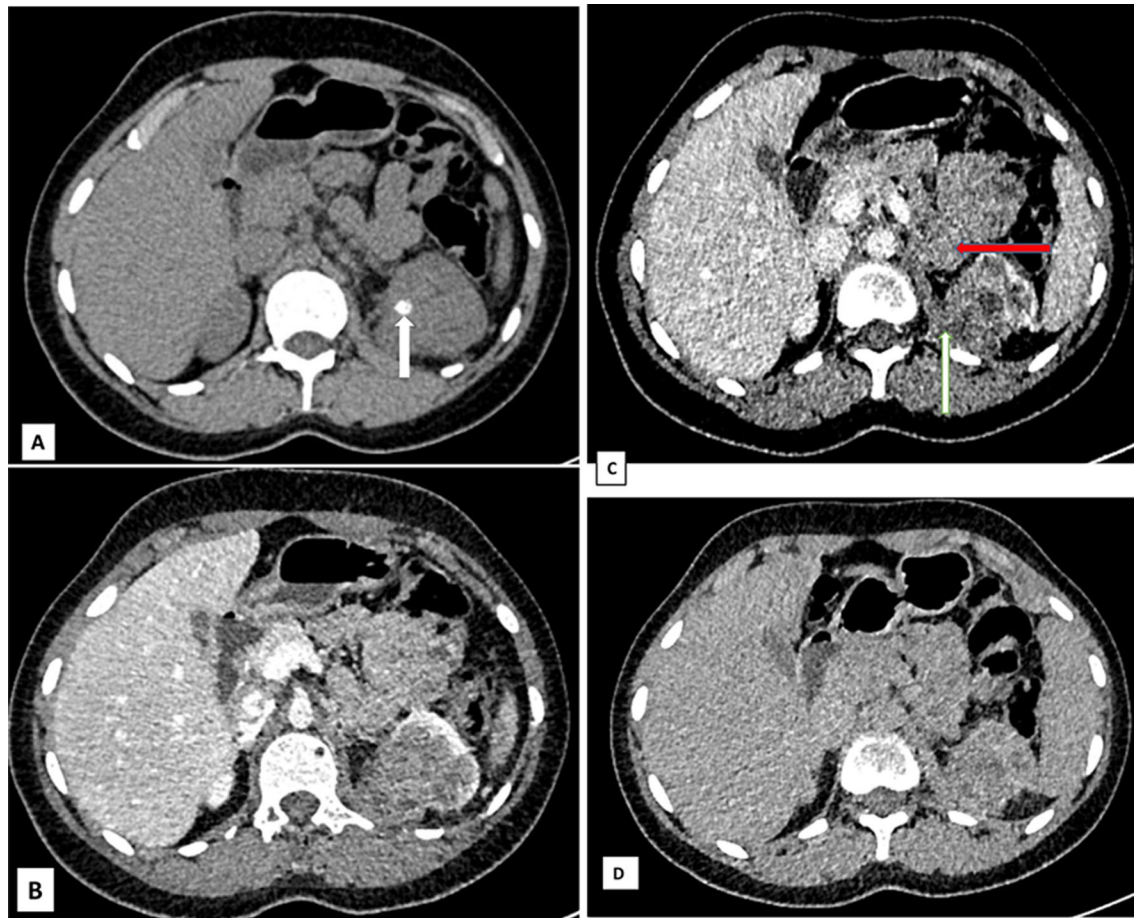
A Axial non contrast CT shows an isodense mass lesion in the upper pole of the left kidney with an eccentric focus of calcification (arrow). B Axial CECT in cortico-medullary phase shows a hypo-enhancing mass lesion in the upper pole of the left kidney, with internal non-enhancing necrotic areas. C Axial CECT in nephrographic phase shows progressive enhancement of the mass lesion in the superior pole of the left kidney. There is extension of the lesion into the left crus of the diaphragm (white arrow) and a metastatic para-aortic node (red arrow). D Axial CECT in delayed phase shows further progressive enhancement of the mass, appearing almost isodense with the adjacent renal parenchyma
